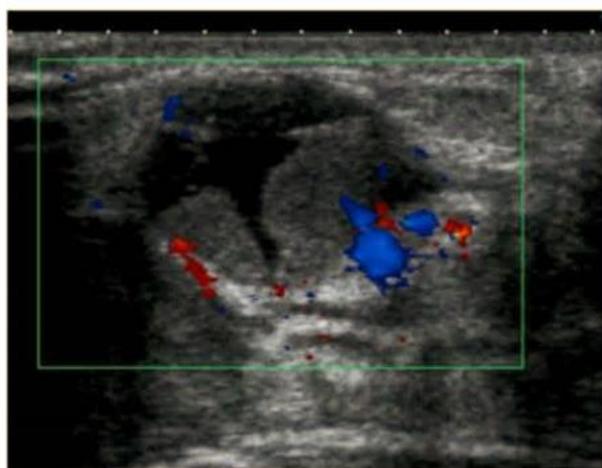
Ultrasound showing a mass of the superouter quadrant of the heterogeneous right breast with dual cystic and tissue components.
